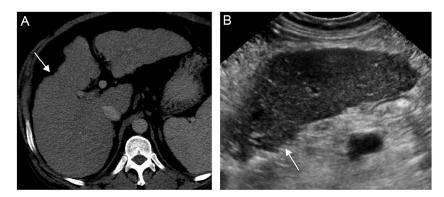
Computed tomography (A) and ultrasound (B) demonstrating irregular, nodular hepatic contours (arrows) compatible with cirrhosis.
